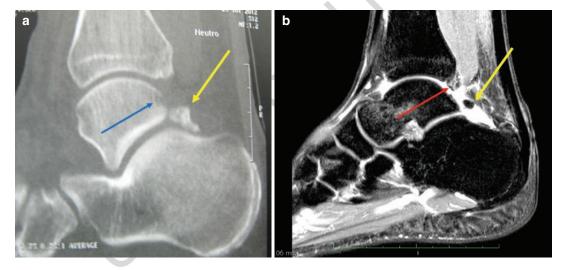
(a) CT sagittal view in which is visible the talar impression (blue arrow) caused by posterior impingement
